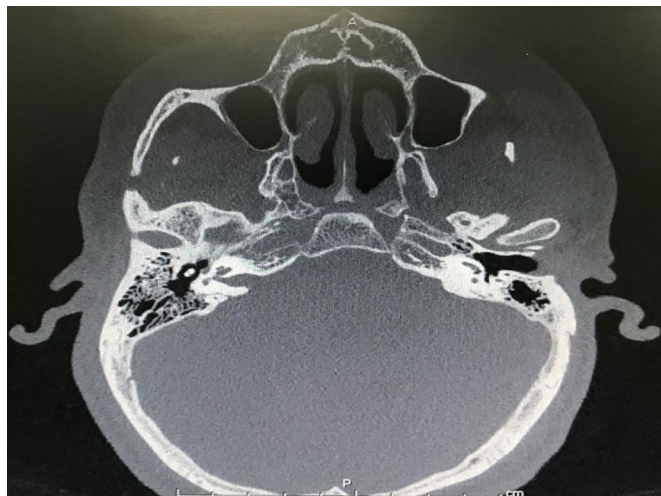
CT scan of temporal bone.
